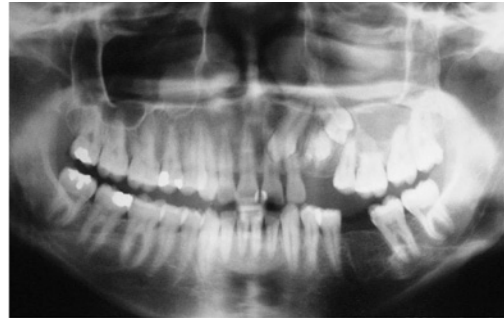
Panoramic radiograph showing displacement of two teeth and a radiopaque mass related to the cystic lesion
